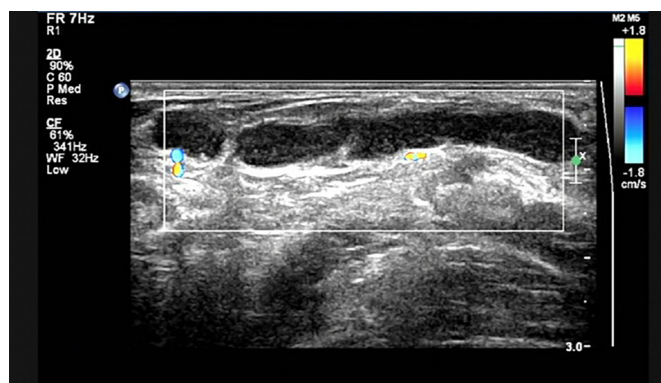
Ultrasound scan showing one of the subcutaneous fluid-filled regions from the left vulva to pubic symphysis that was multilocular and mobile.
